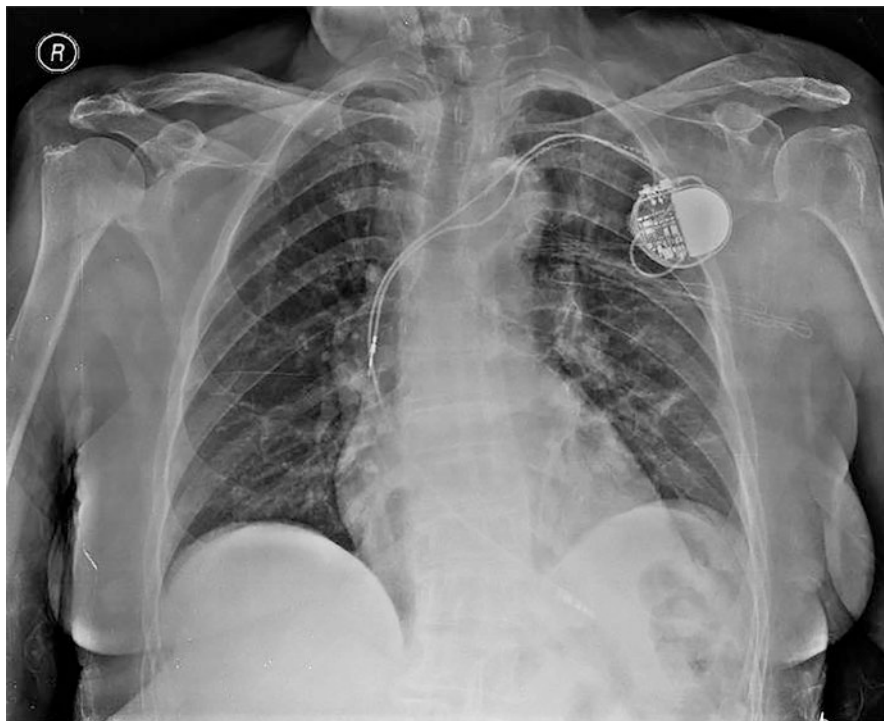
Anteroposterior chest X-ray of a patient with dislodged and inactivated atrial lead
